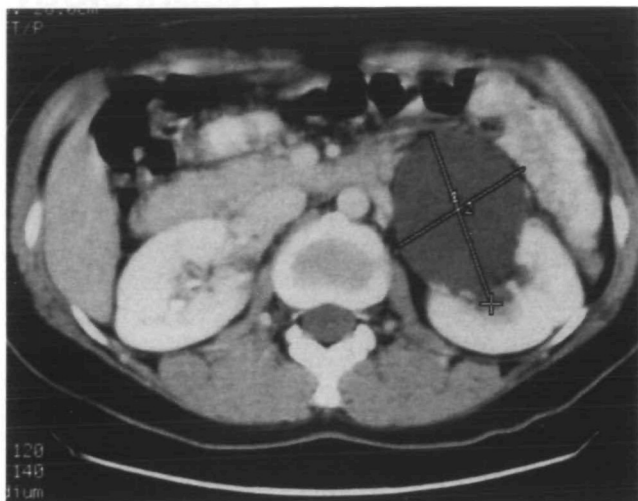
Abdominal computed tomography showed 6.7 × 5.4 cm large cystic mass in the left renal hilum suggesting parapelvic cyst.
